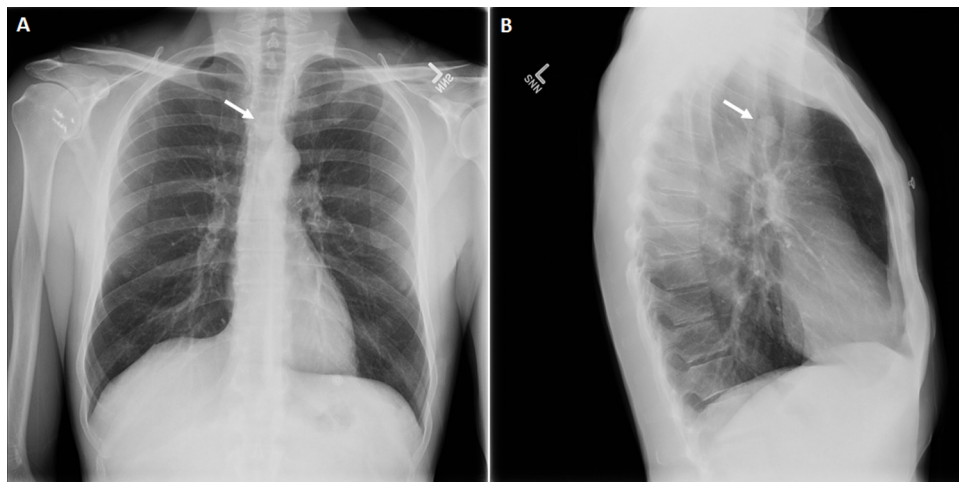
Chest x-ray (A) anterior-posterior and (B) lateral showing rounded opacity within trachea approximately 5 cm above the carina, just inferior to the clavicular heads (arrow).
